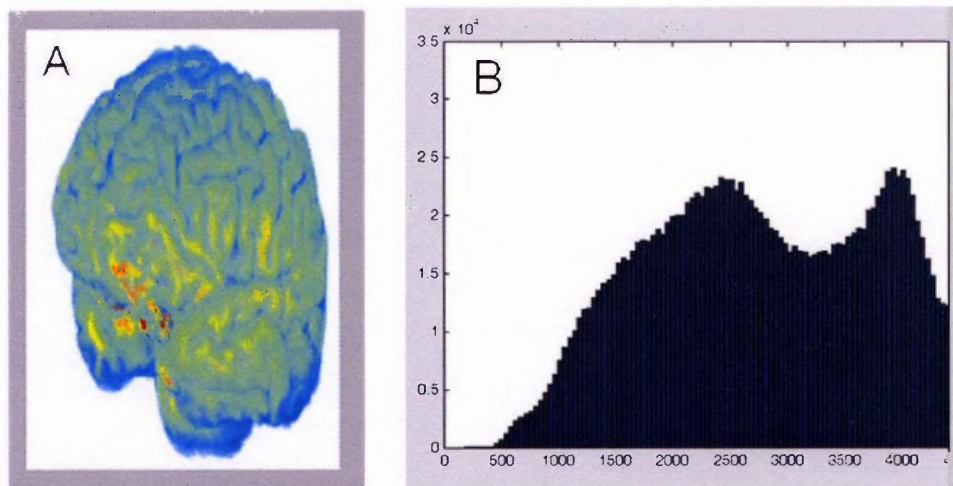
A- Brain map using MRI; B-histogram of the brain map.
